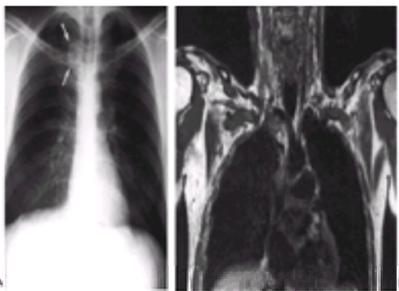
A: Chest radiograph demonstrating a 2-cm peripherally calcified mass in a right paratracheal location. A vascular origin should be suspected in any chest lesion with peripheral curvilinear calcification. B: A coronal MRI displaying a pseudoaneurysm of the right subclavian artery in a patient with a remote history of a penetrating knife wound.
